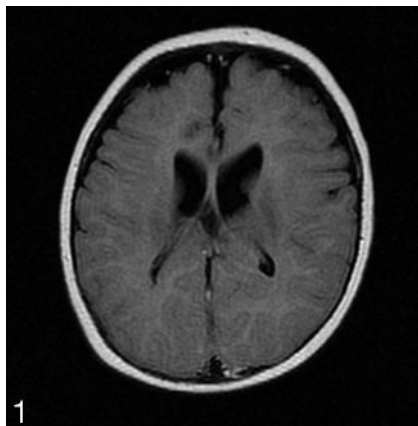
Axial fluid-attenuated inversion recovery MR image showing prominent CSF equivalent subarachnoid spaces in both frontal regions. No subdural hemorrhage is noted.
